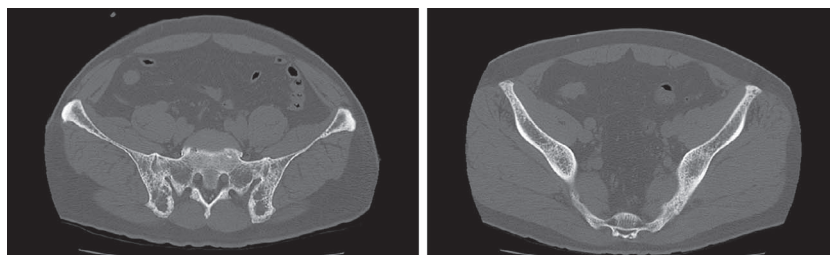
The patient's CT findings in his pelvic bone.
